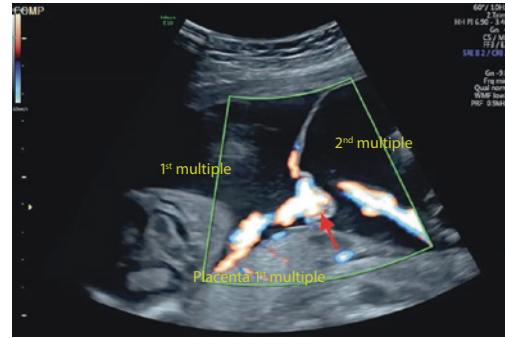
Abdominal sonography and color Doppler showing the amniotic cavities of dichorial twins; velamentous cord insertion of the 1st multiple in the partition wall (red arrow) and additional velamentous vessels in the 19th week of gestation
